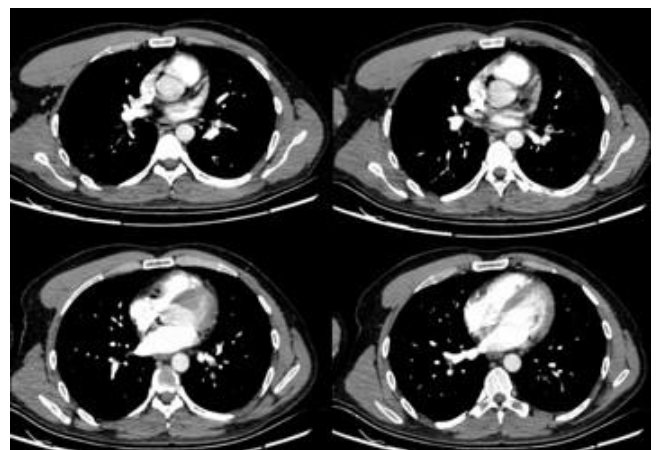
Thorax computed tomography at admission showing thrombus in the left lower lobe pulmonary artery
